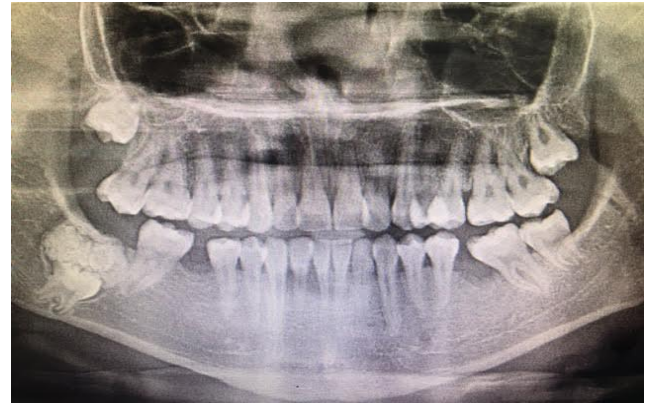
Panoramic radiograph shows a multiple radiopaque mass surrounded by a thin radiolucent rim associated with the lower right third molar tooth.
